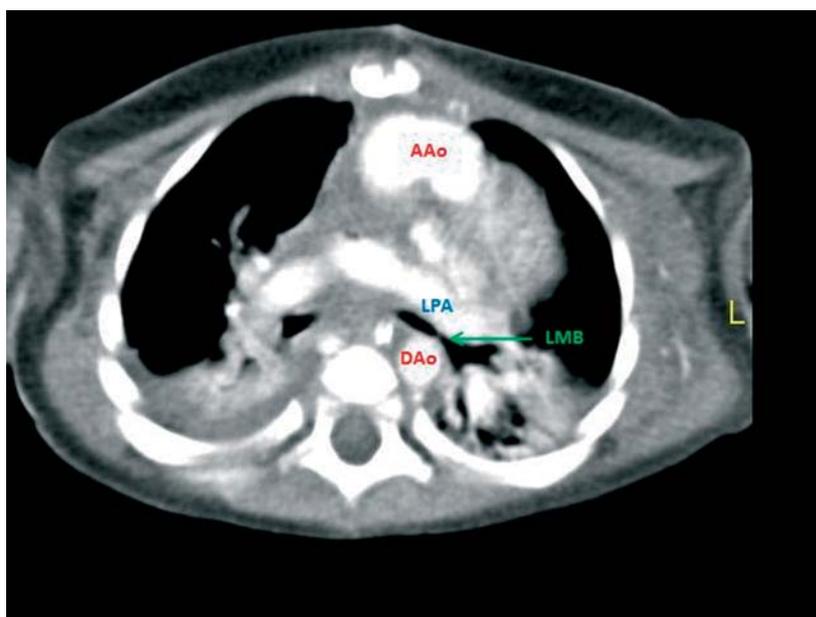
Slice CT scan showing the discrete obstruction in the left main bronchus with the left pulmonary artery directly anterior and the descending aorta directly posterior to the site of obstruction.
